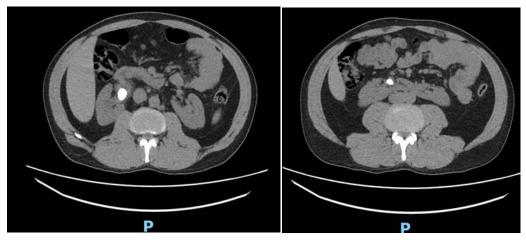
CT KUB (axial sections) Showing Right Pelvic and Lower Pole Calculi with Fused Lower Poles - Isthmus
